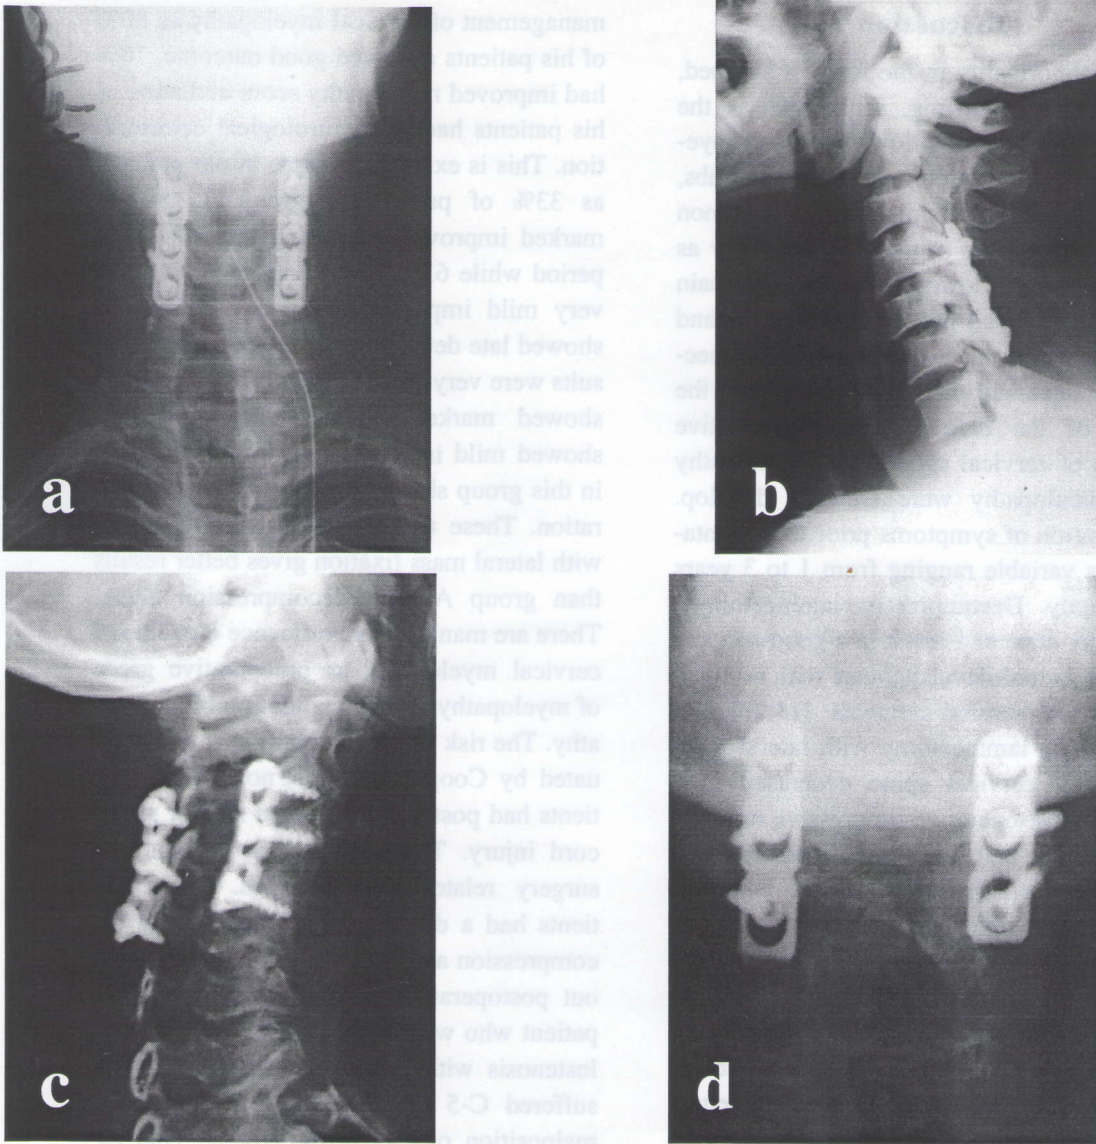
a, b c, d): Postoperative plain x-ray showing plates and screws in position.
